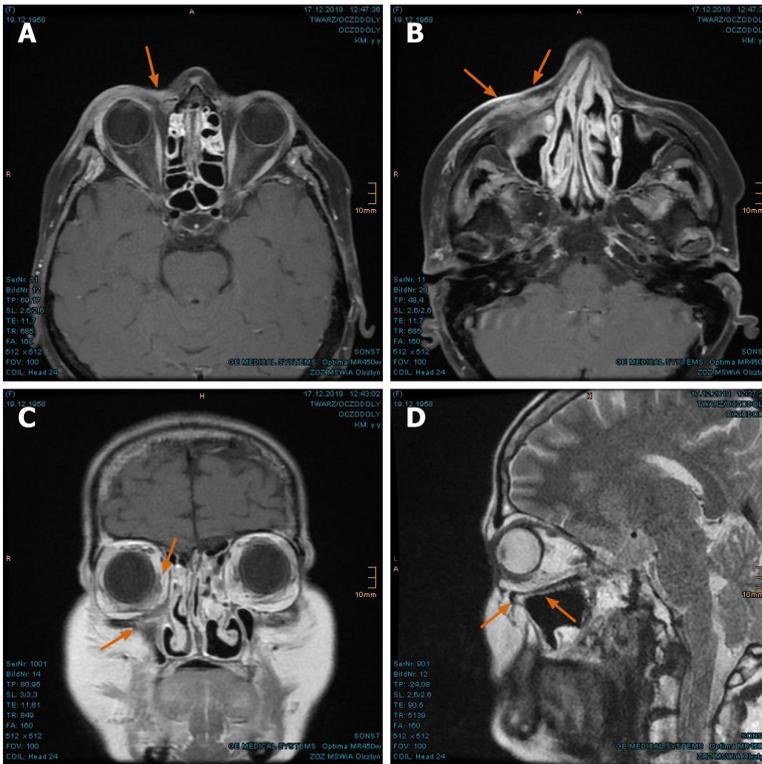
Complete tumor remission verified in the magnetic resonance imaging at 8 mo after proton beam therapy. A: Further regression of the tumorous enhancement in the right lacrimal sac marked with arrows; B: Post-radiogenic changes of the right facial soft tissue with no evidence of residual tumor; C: Coronal presentation of the fully regressed right peri-orbital sinonasal cancer; D: Clearly defined orbital floor with normal position of the right eye.
